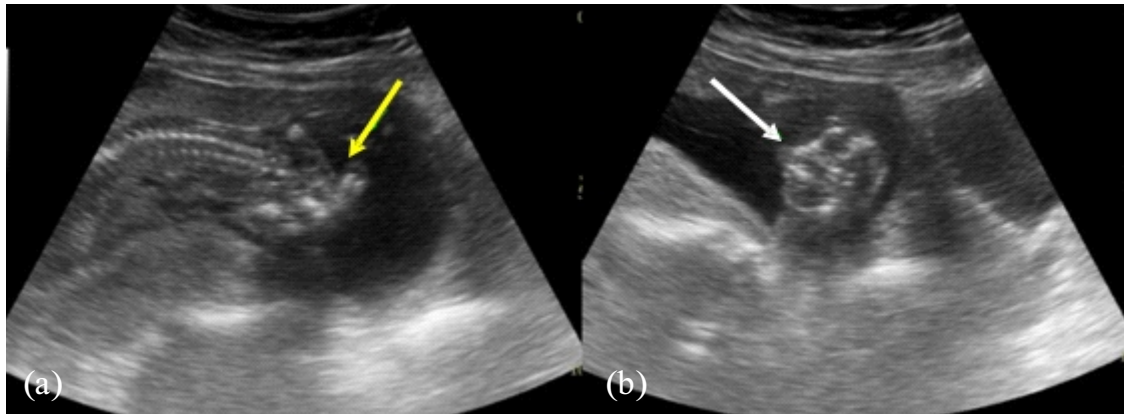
(a) Ultrasonography on sagittal plane showed absence of cranial vault (yellow arrow). (b) On coronal plane, prominent orbits were clearly shown (white arrow).
